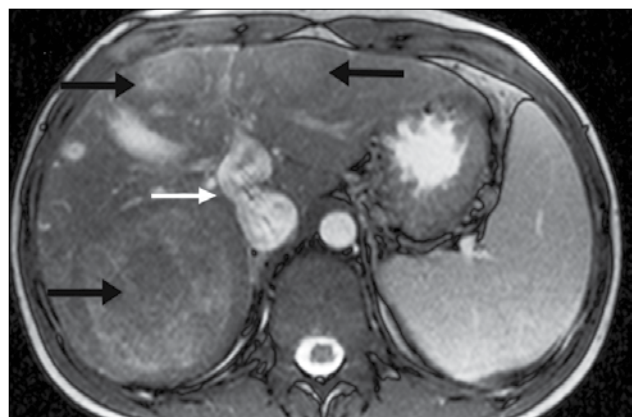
Axial view of liver magnetic resonance imaging scan showing the shunt (white arrow) and associated hepatic tumours (black arrows).
